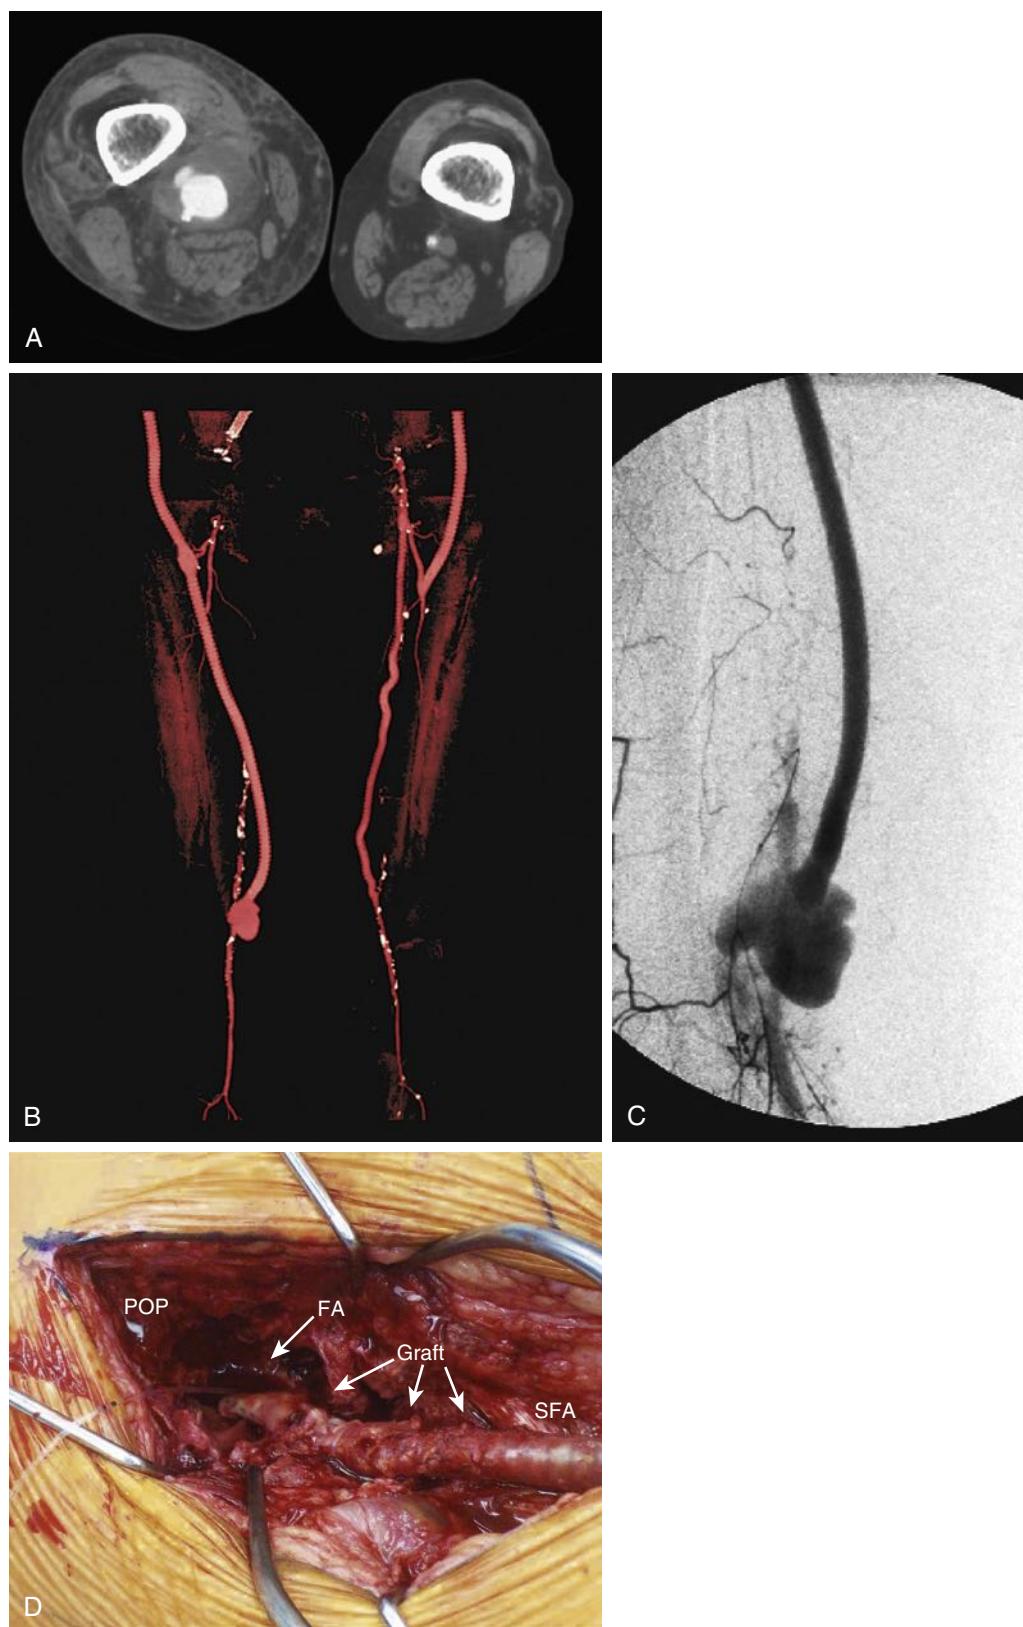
Infected Anastomotic Aneurysm Involving the Distal Femoropopliteal Bypass Graft. (A) Axial computed tomographic images from a preoperative angiogram. (B) Reconstructed images from a preoperative computed tomographic angiogram. (C) Intraoperative angiogram demonstrating a false aneurysm. (D) Degenerated polytetrafluoroethylene graft to the popliteal artery (POP) anastomosis. FA, false aneurysm; SFA, superior femoral artery.
